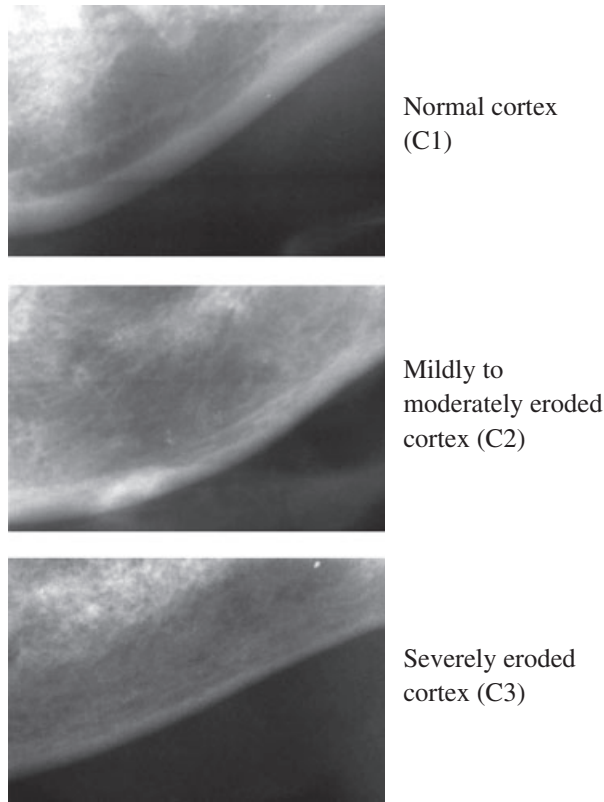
Mandibular inferior cortex classification (MIC) on dental panoramic radiographs
